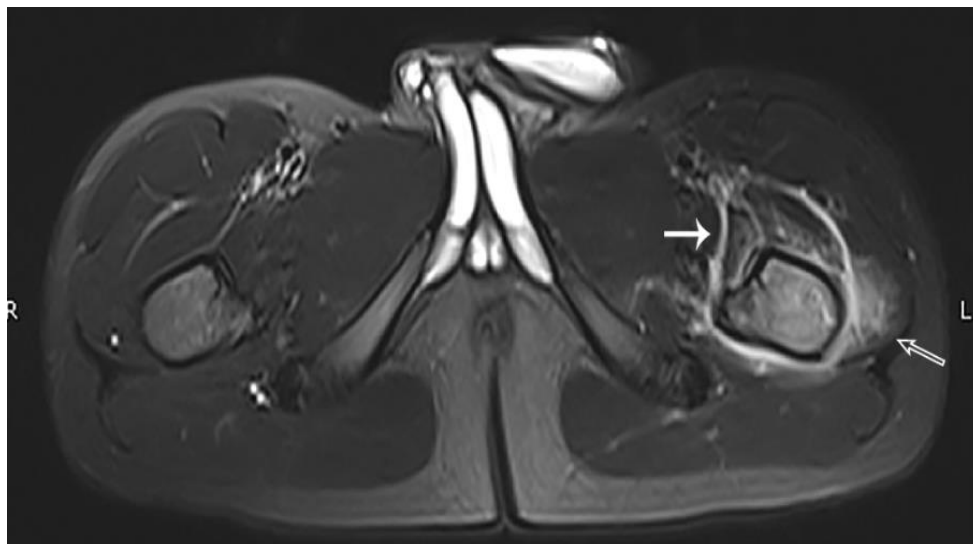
MRI showing high signal edema around the left femur and surrounding hip musculature suggestive of chronic osteomyelitis
